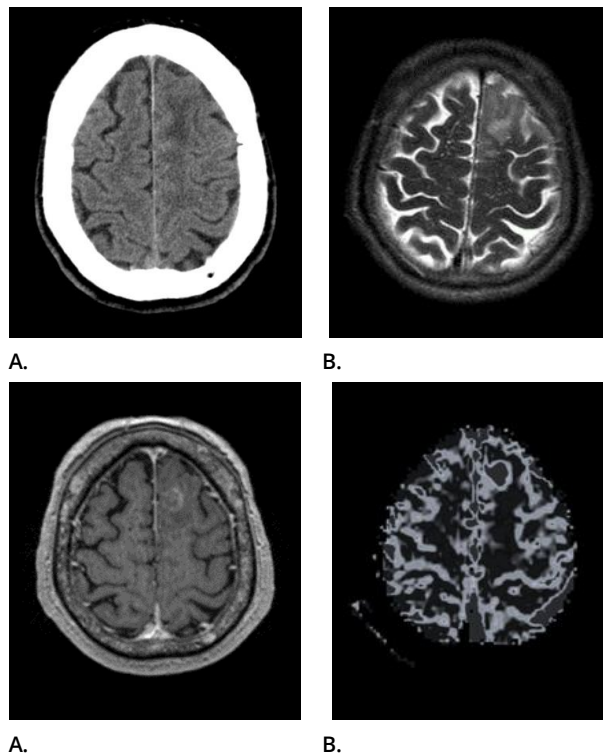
(Case No. 2): A, B. CT scan and MRI scan at first symptoms; C, D. Contrast enhanced MRI and perfusion MRI 6 months later.
